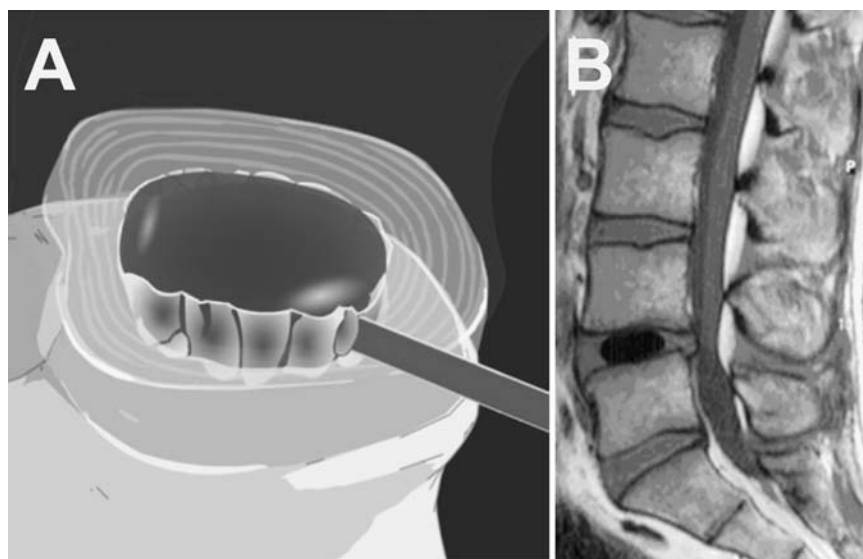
The DASCOR™ disk arthroplasty device is injected as a liquid under pressure through the catheter (A). A sagittal MRI (B) demonstrates the cured injectate in situ. (Courtesy of Disk Dynamics, Inc., Eden Prairie, MN.)
